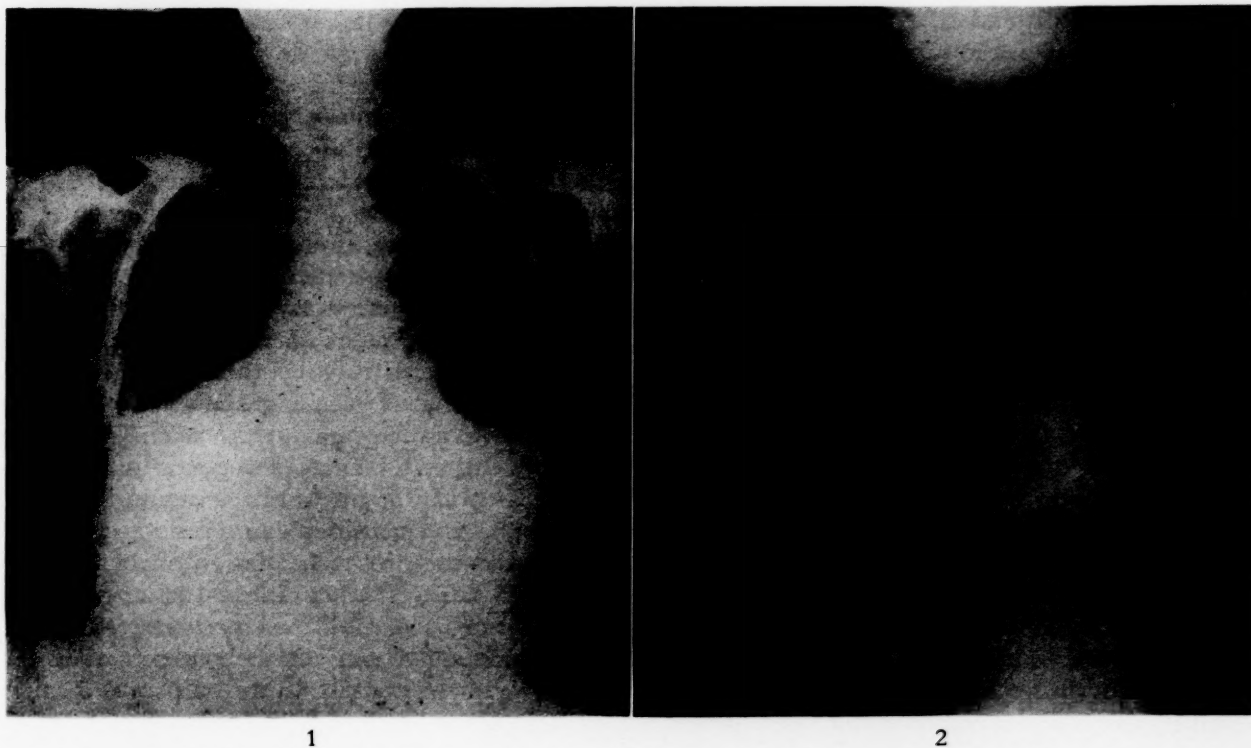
Case 1. Radiograph of the chest taken the day of appearance of the subcutaneous emphysema. The widened mediastinum and partial atelectasis of the lower lobes is due to the elevation of the diaphragm from abdominal distention. Mediastinal emphysema is not present. The subcutaneous emphysema extends from the abdominal to the neck areas.
